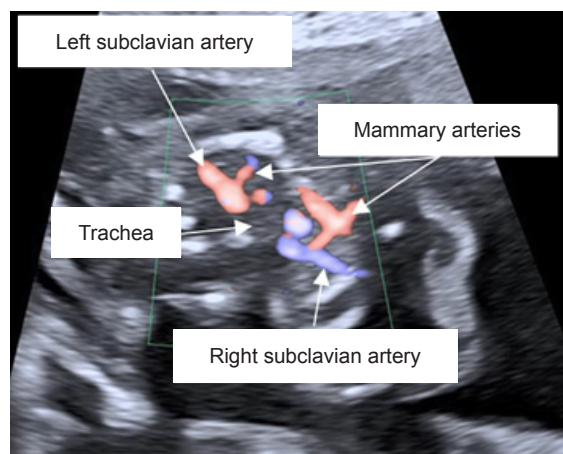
Fetal echocardiogram (color flow axial image) showing the left and the right subclavian arteries arising from the left and the right aortic arches, respectively.
